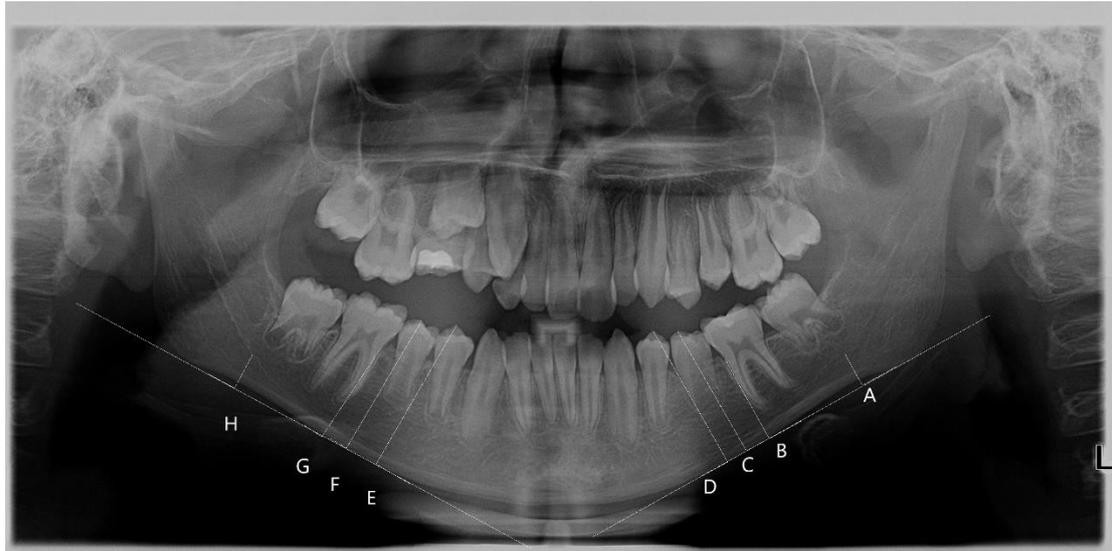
Panoramic radiograph showing the sites (A–H) where measurements of the width of the cortical bone were done. Lines were drawn perpendicular to a tangent at the lower border of the cortex to the inner border of the cortex at A and H (the deepest points of the antegonial notch concavity), at the cemento-enamel junction of the crown of the first molar (B, G) and at the highest cusp of the premolars (C, D, E, F). The width of the cortex was measured along these lines.
